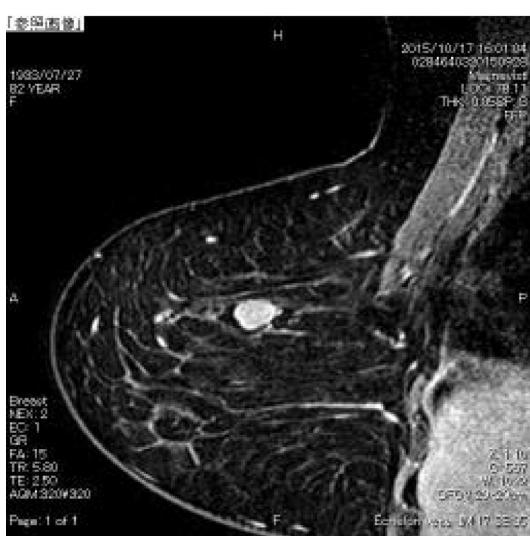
Contrast-enhanced MRI shows a localized, well-enhanced mass but no extensive intraductal component.
